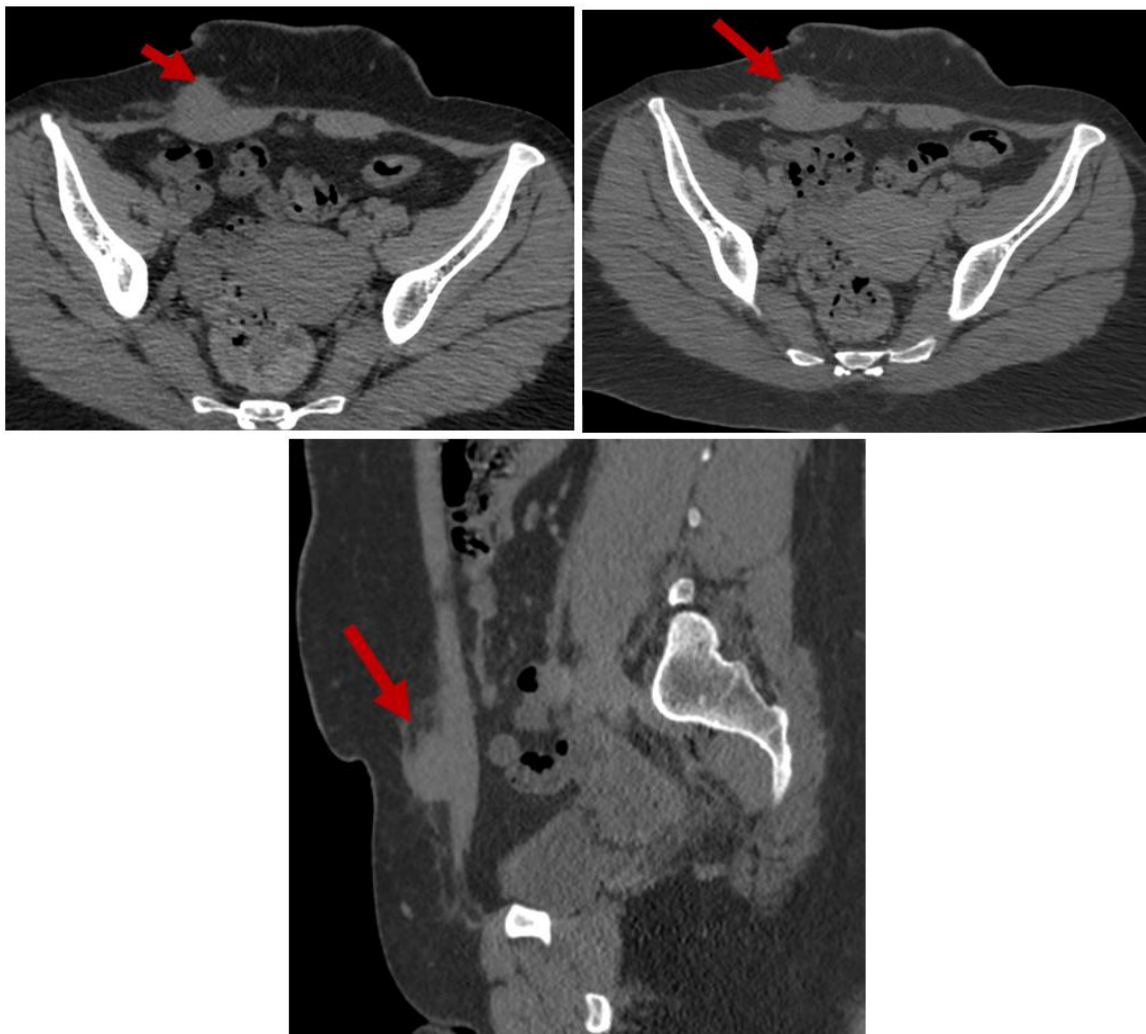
Axial and sagittal with and without contrast CT scan. Heterogeneous soft-tissue mass with mild peripheral enhancement at the level of the cesarean section scar
